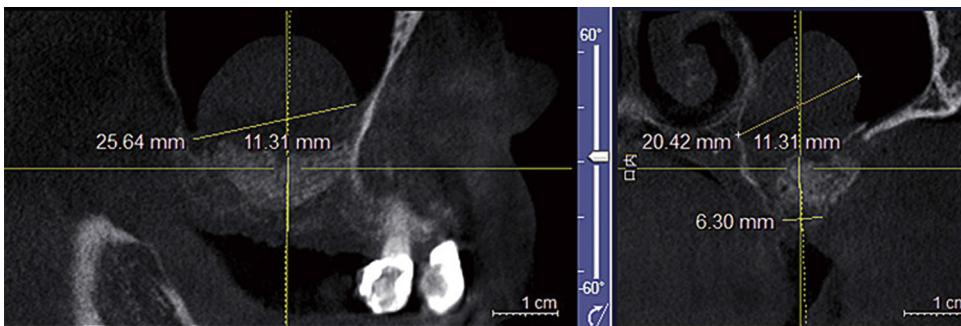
CT show the crestal bone height between sinus floor and alveolar ridge of first molar was elevated to 11.31 mm. The cyst (25.64 mm × 20.42 mm) was complete and supported by the window wall and allograft. The sinus lumen was isolated from the grafted sub-sinus space.
